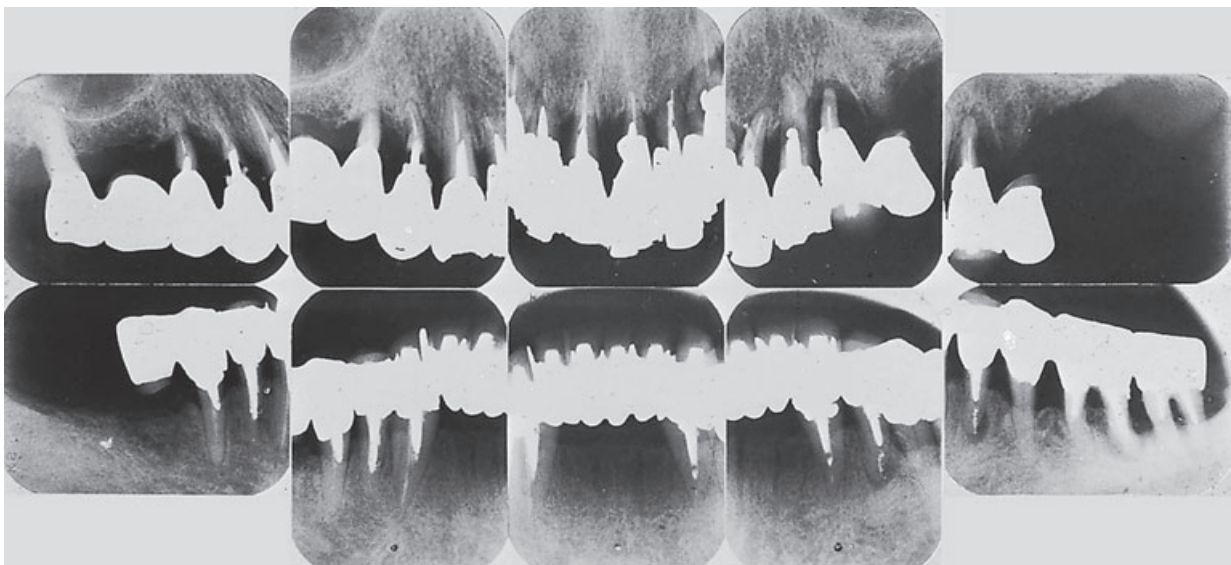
Case C, 52-year-old female. Radiographs obtained at the initial examination.
